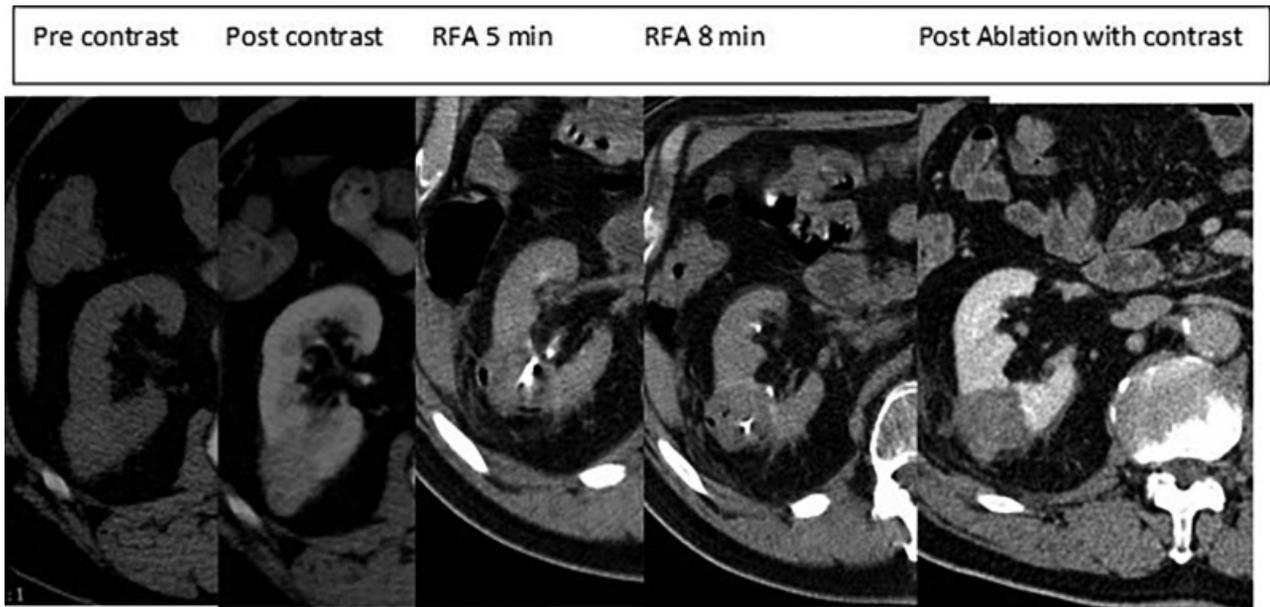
Radiofrequency ablation (RFA) of posterior papillary renal cell carcinoma in a 66-year-old man. On axial CT images precontrast, lesion is characteristically hyperdense and hypoenhancing postcontrast. On RFA images, lesion with RF probe is noted at 5 minutes and becomes hypointense during ablation with gas bubbles at 8 minutes. Postablation, the lesion is markedly hypodense and nonenhancing with a wedge-shaped region of thermally induced infarction.
